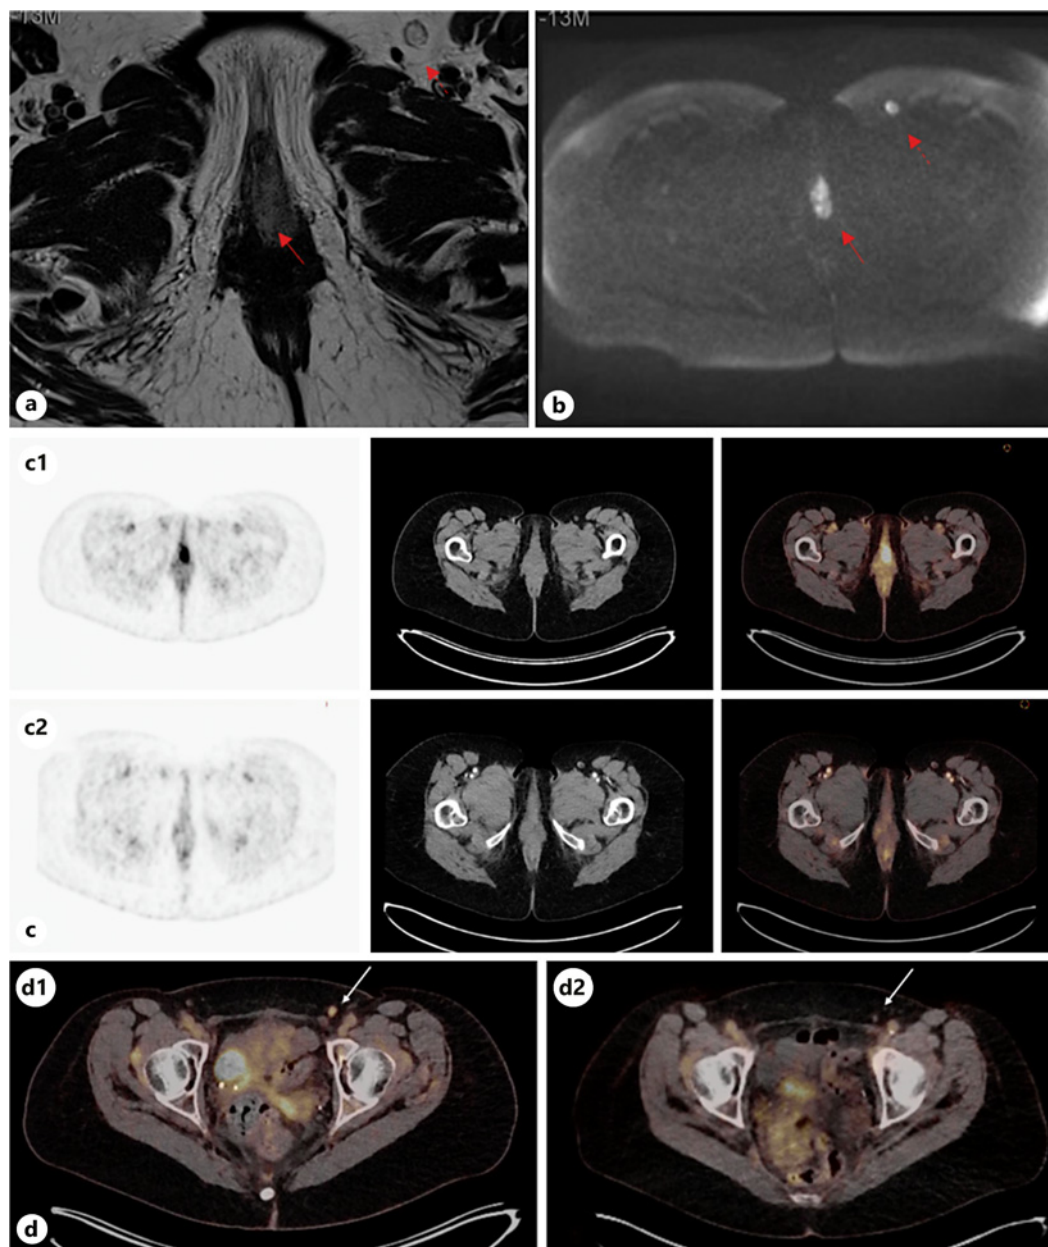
Imaging of the vulvar metastasis. a MRI T2 sequence. The solid arrow indicates the vulvar lesion. The dotted arrow indicates the node in the left iliac region. b MRI diffusion sequence. The solid arrow indicates the vulvar lesion. The dotted arrow indicates the node in the left iliac region. c PET scan showing the vulvar metastasis (c1) and its regression (c2). d PET scan. The arrow indicates the node in the left iliac region (d1) and its regression (d2).
